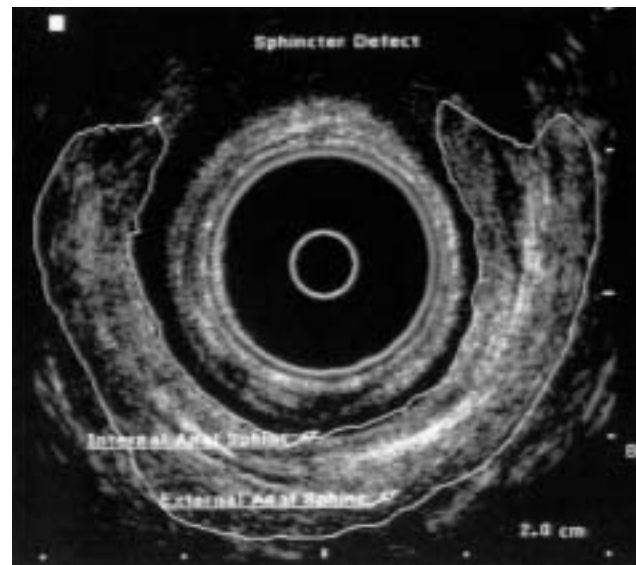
Endoanal ultrasound study with use of 10-MHz probe. Orientation shows vagina at the top of the figure and coccyx at the bottom of the figure. Note the complete disruption of the external anal sphincter anteriorly due to prior obstetrical injury (sphincter defect). The internal anal sphincter appears as a hyperechoic ring, whereas the external anal sphincter is a more heterogeneous hyperechoic area. The center black area represents the ultrasound transducer.
